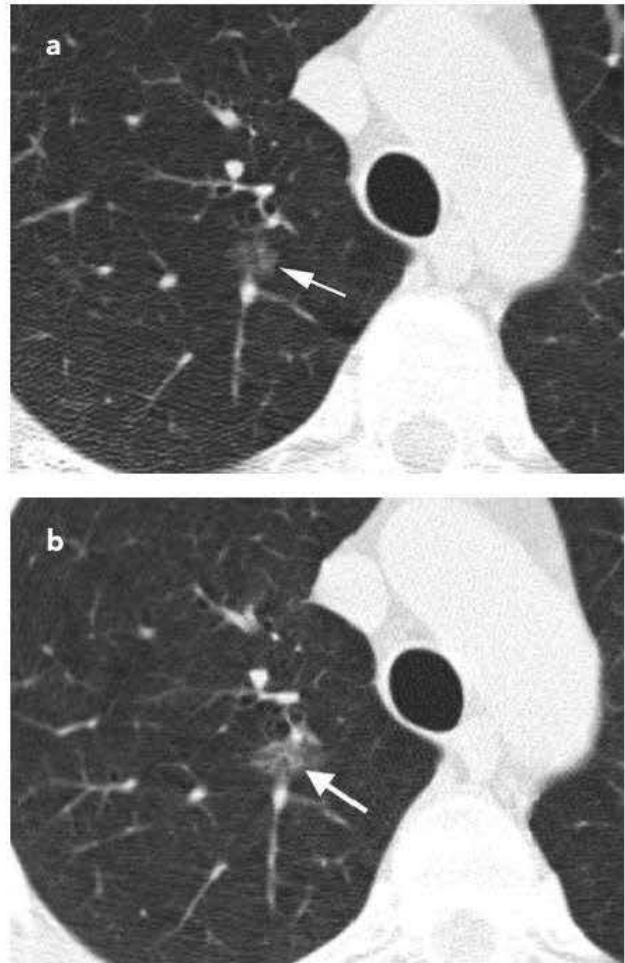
CT scans in a 57-year-old man undergoing low-dose lung cancer screening. (a) Baseline scan shows a right upper lobe pure ground-glass nodule measuring 11 mm (arrow). Nodule was classified as Lung-RADS category 2. (b) CT scans obtained at second annual follow-up show that this nodule grew to 15 mm (arrow). Malignancy was subsequently diagnosed.
